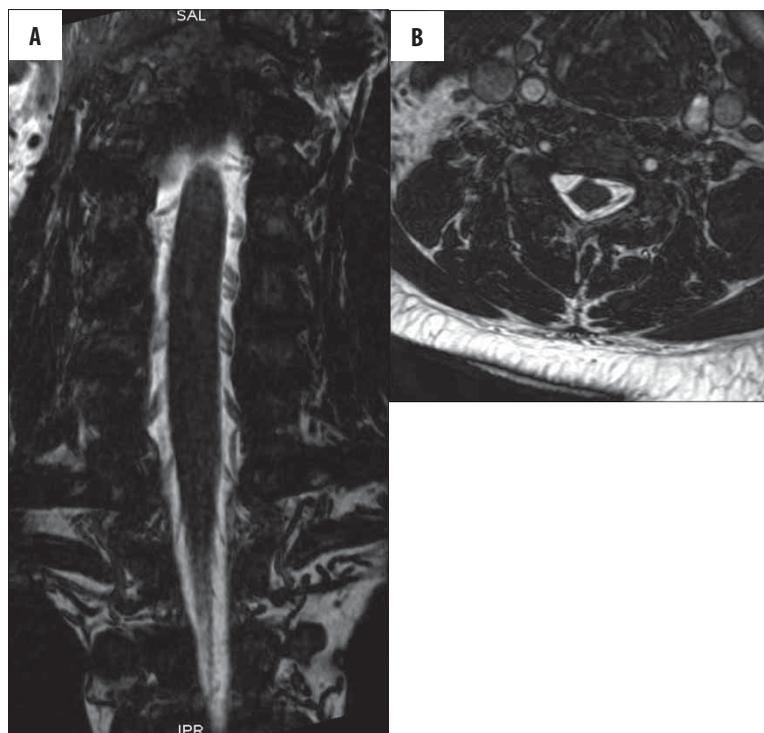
Traumatic avulsion injury of the right C6 spinal root. High-resolution sagittal (A) and axial (B) T2-weighted images reveal lack of the right C6 root (compare with the normal appearance on the left).
